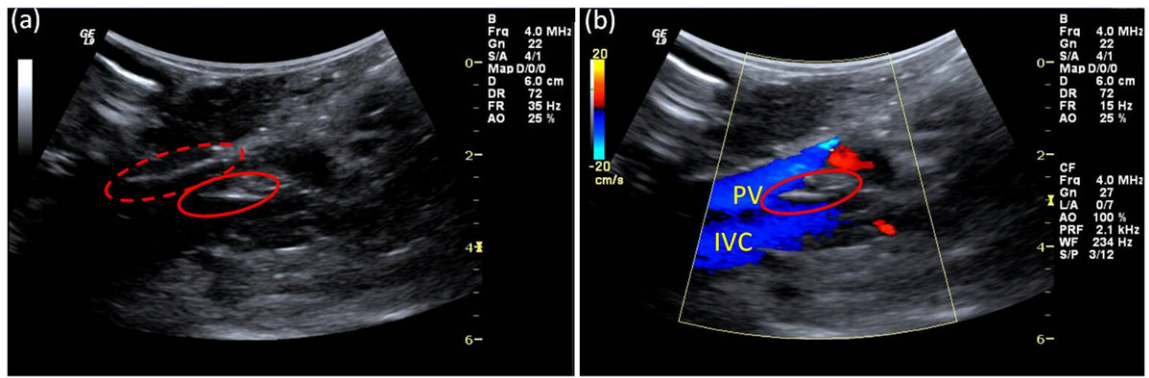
Grayscale B-mode and color Doppler images acquired during data acquisition. (a) The locations of the surgical inlet (red-dotted ring) and the pressure catheter (red ring) are indicated. (b) Color Doppler image verifying the presence of pressure catheter (red ring) in the portal vein (PV); inferior vena cava (IVC) is shown as well.
